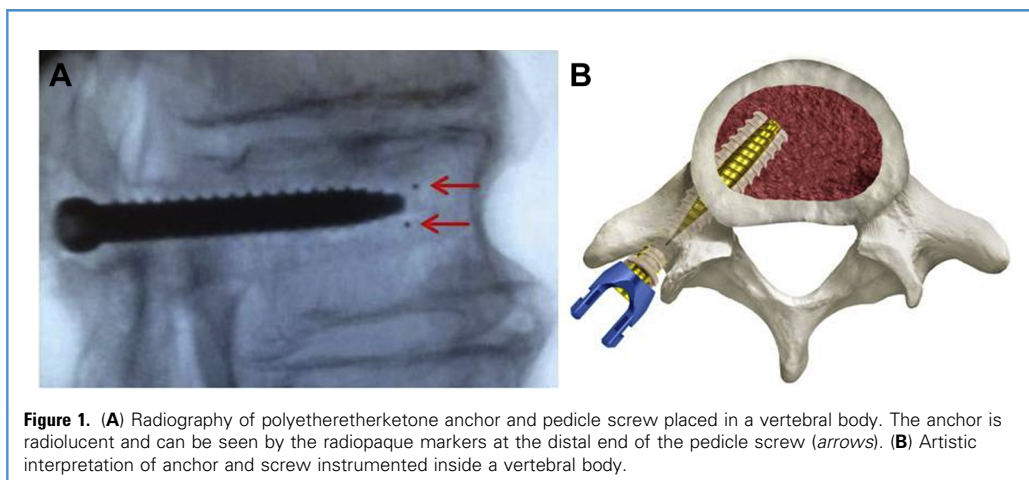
(A) Radiography of polyetheretherketone anchor and pedicle screw placed in a vertebral body. The anchor is radiolucent and can be seen by the radiopaque markers at the distal end of the pedicle screw (arrows). (B) Artistic interpretation of anchor and screw instrumented inside a vertebral body.
